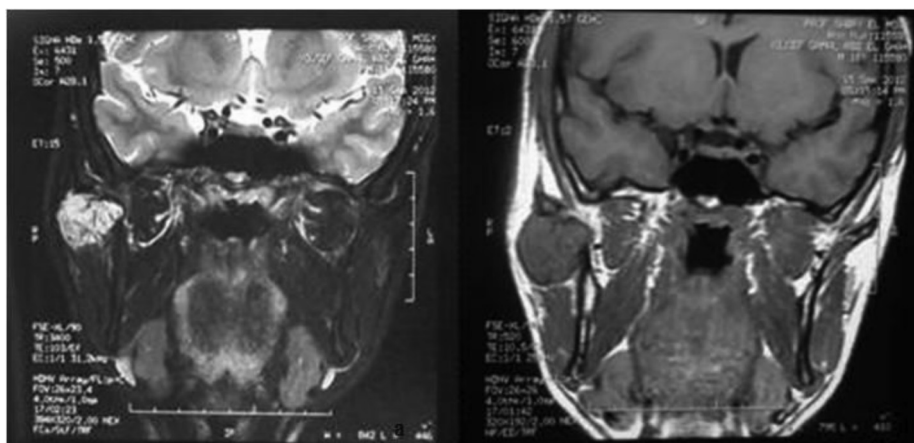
MRI of a hemangioma in the superior part of the parotid gland. Note the strong signal produced by the tumor on T1 (a) weighted images, the weak signal produced on fat suppressed images (b), and the clearly-defined margin of the tumor. Note the extension of the mass to the condylar head.
